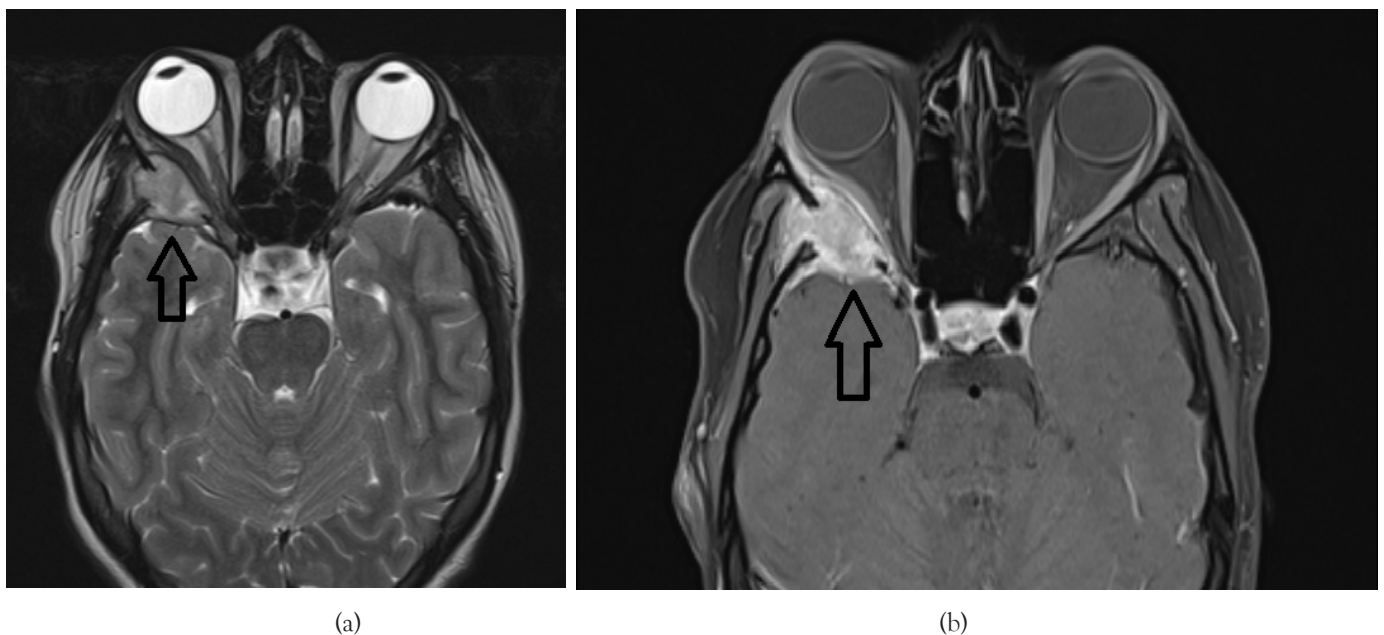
Axial sections of brain MRI (arrow) showing a nodular lesion hyposignal T2 and isosignal T1 (a) and intensely enhanced after injection (b).
